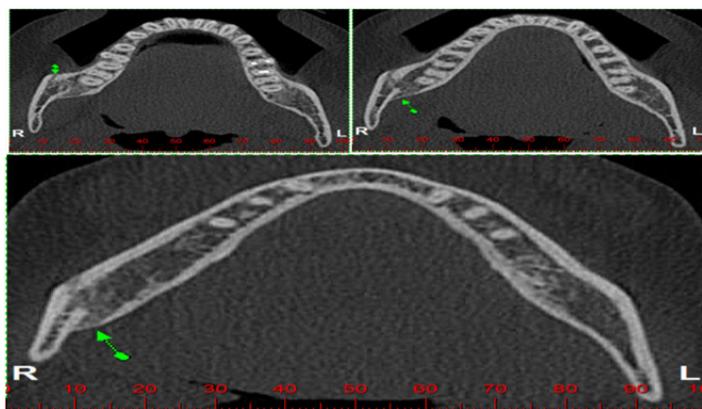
Cone-beam CT 195 days after the fracture, showing good bone healing.
